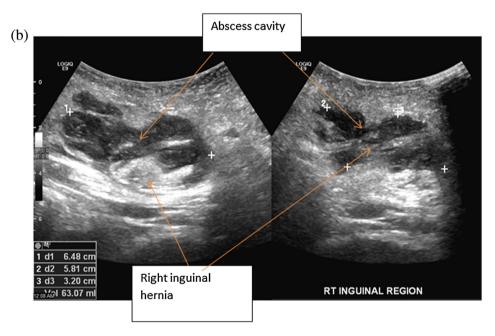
(A&B): Abdominal ultrasound showing the abdominal abscess and inguinal hernia.
